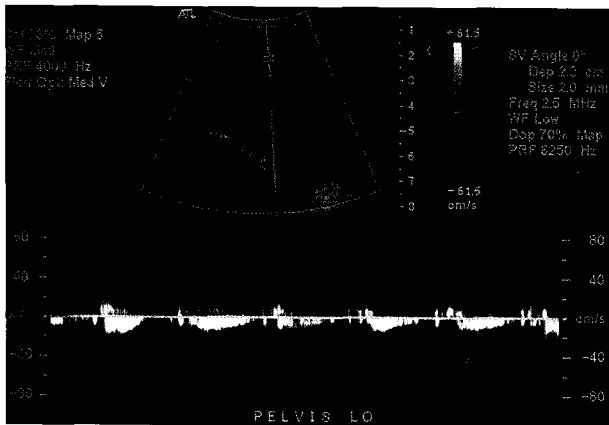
Ultrasonography on pelvis area showing turbulent vascular flow in the center of mass.
